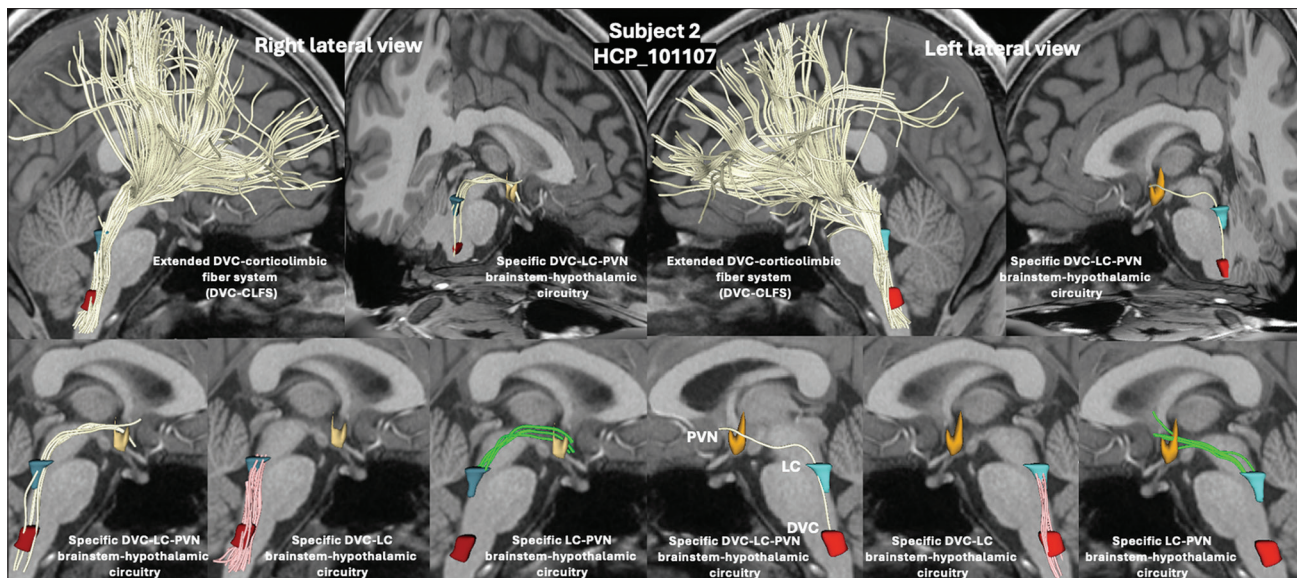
The complete results of diffusion magnetic resonance imaging tractographic analysis for Subject 2 (HCP_101107).
